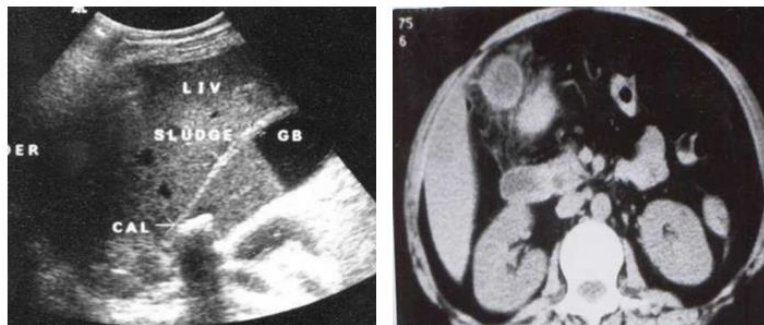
A & B : Sonography showing hyperechoic sludge & calculus in GB, suggesting Cholelithiasis. NCCT image showing pericholecystic fat stranding in a case of Cholelithiasis
